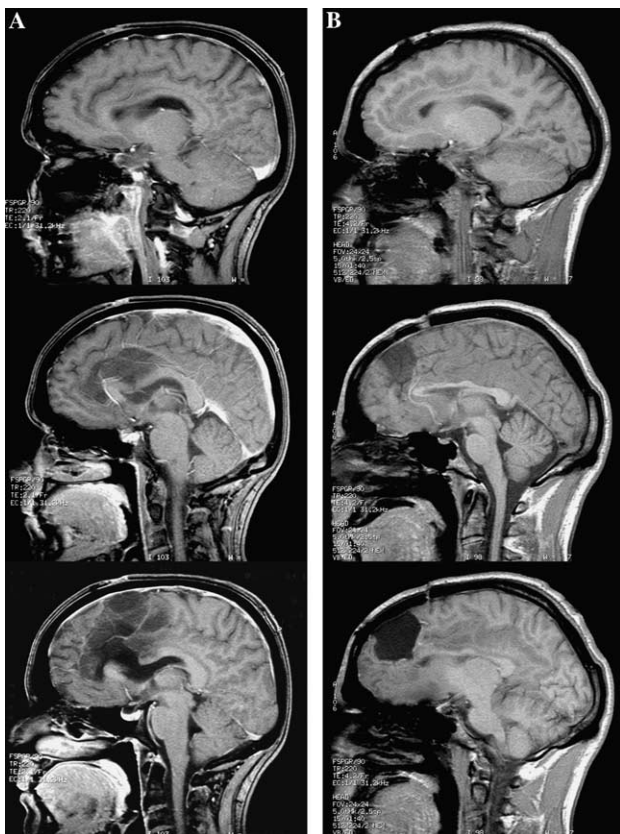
MRI of lesion of (A) Patient 1, including unilateral right ACC lesion, and (B) Patient 2, including bilateral ACC lesion. For detailed description of lesions see text.
